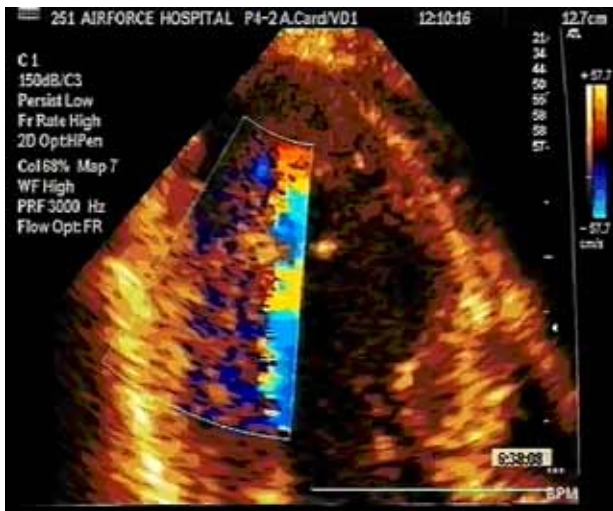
Two-dimensional echocardiogram, three-chamber apical view. The colour flow demonstrated communication between intertrabecular spaces and the left ventricular cavity (posterior wall).
